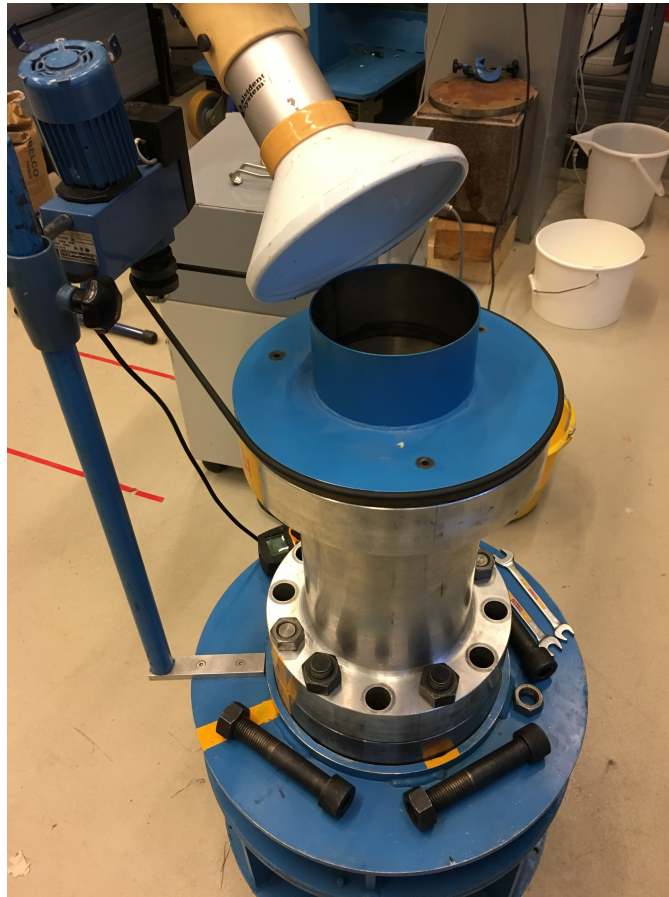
CT cell on base pedestral with silo
